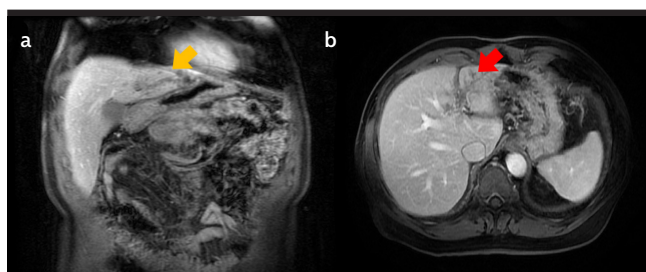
a, b. Abdominal MRI at 3 months of sorafenib therapy. a) Significant improvement in the multinodular expression, being confined to residual millimetric nodules without contrast uptake (yellow arrow). b) Marked reduction in portal vein thrombosis without arterial enhancement (red arrow).
